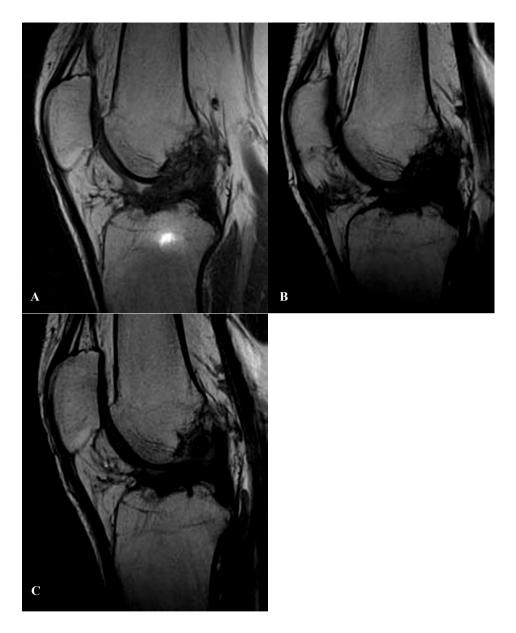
Clinically stable ACL after primary repair with Dynamic Intraligamentary Stabilization without signs of healing on MRI. Sagittal proton density weighted MR image at 6 months (A) post-operatively shows irregular appearance of the ACL with abnormal ligament strands and extensive fibrosis at the intercondylar notch. Follow-up MRI assessments at 12 (B) and 24 (C) months post-operatively remain unchanged.
